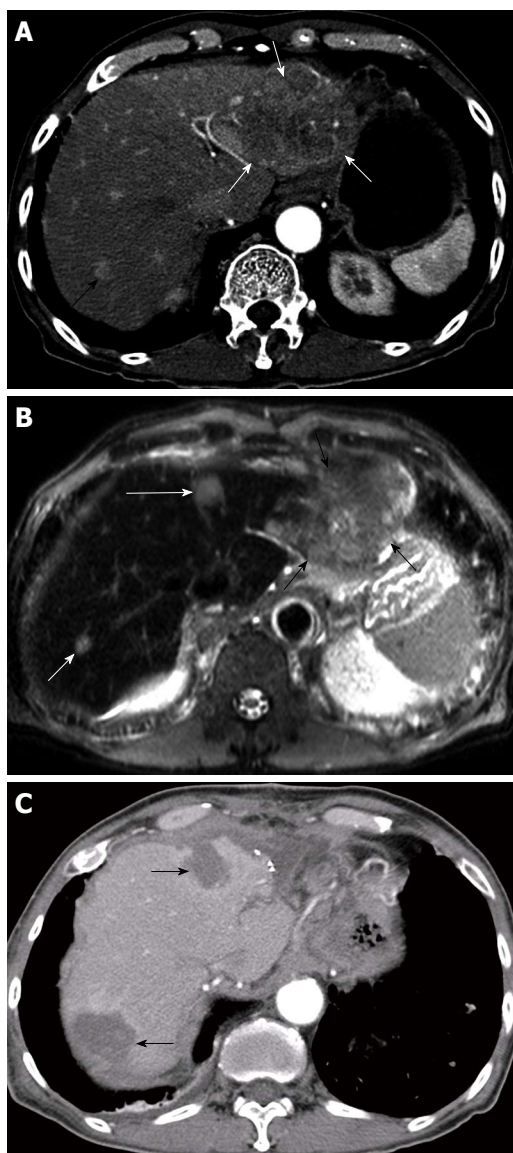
Successful radiofrequency ablation (RFA) combined with hepatic resection for multifocal hepatocellular carcinomas (HCCs) in a 74-year-old man. A: Contrast-enhanced transverse helical CT scan obtained during the arterial phase before treatment shows two HCCs in the both hepatic lobes. There are 11.0-cm-diameter HCC (white arrows) in left lateral segment and 1.1-cm-diameter HCC (black arrow) in liver segment 7; B: Ferucarbotran-enhanced T2-weighted fast spin echo MR image shows another 1.5-cm-diameter HCC (long white arrow) in liver segment 4. He underwent resection for a large tumor and concurrent RFA for two small tumors; C: Contrast-enhanced transverse helical CT scan obtained 1 mo after combined hepatectomy and RFA shows two round ablation zones (arrows) of low attenuation that suggests technical success of ablation. At 4 mo after treatment, multiple metastatic tumors were found in the both lungs (not shown).
